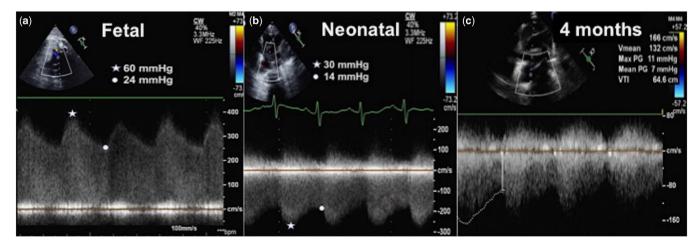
Changing gradients. Serial Doppler tracings from fetal (*a*), neonatal (*b*), and at 4 months of age (*c*) showed reducing gradients owing to progressive fall in pulmonary vascular resistance.
